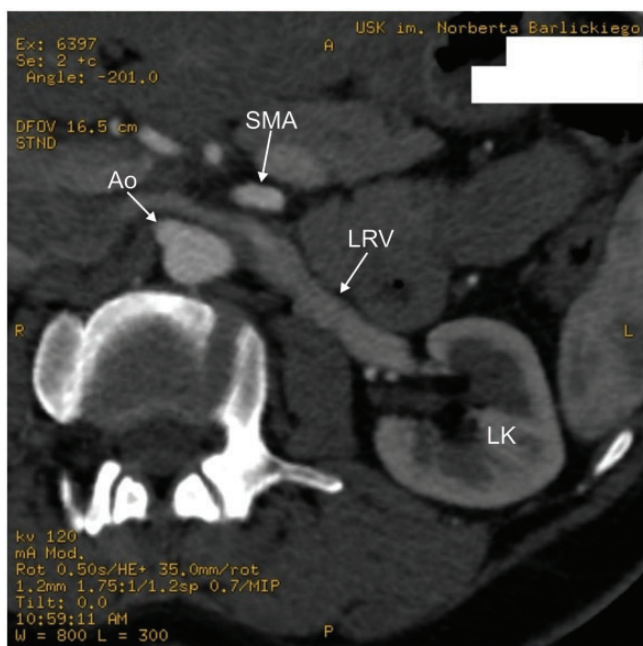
Helical computed tomography (CT) angiography, transverse scan at the L2 level, showing the left renal vein (LRV) compressed between the abdominal aorta (Ao) and the superior mesenteric artery (SMA); the left kidney (LK) is also shown.
